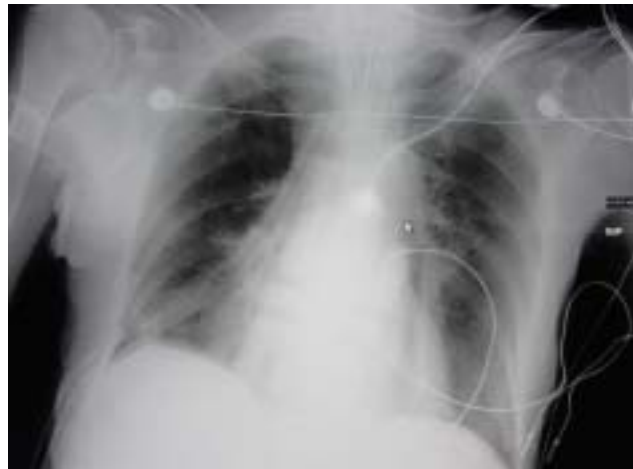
Post-operative chest x-ray revealing complete re-expansion of the right lung after removal of the grape.
